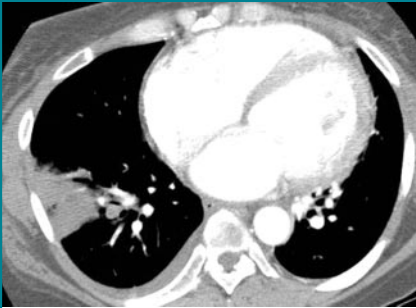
Transverse CT scan shows pulmonary infarction.
